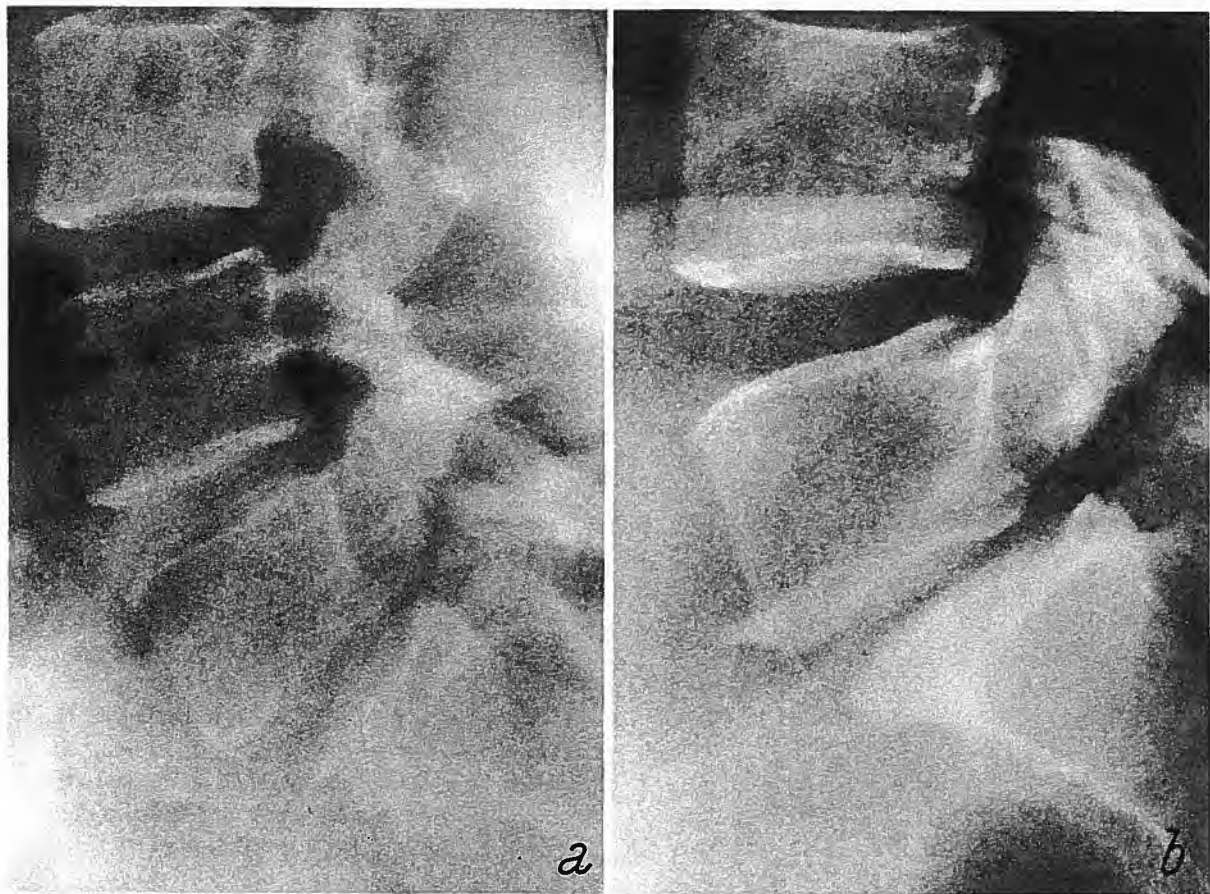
Antero-posterior and lateral radiographs of the lower lumbar spine in a 21 year-old male with Grade 1 spondylolisthesis. Spondylolytic defects are visible at L5/S1 but the lamina is grossly abnormal with spina bifida occulta. In such patients, if surgery is contemplated, myelography is essential
